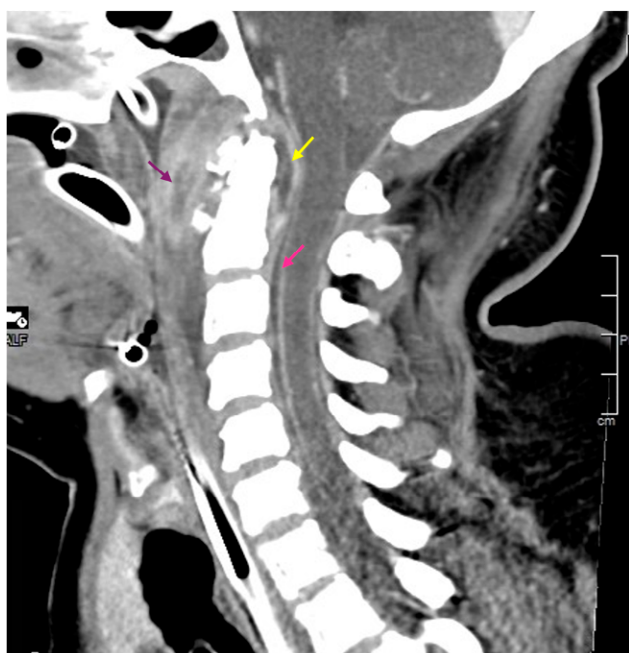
Head and neck CT scan sagittal view: perimedullary enhancement suggestive of leptomeningitis (pink arrow), subligamentous abscess (yellow arrow) and thickening and densification of the posterior pharyngeal wall with an abscessed cavity (purple arrow)
